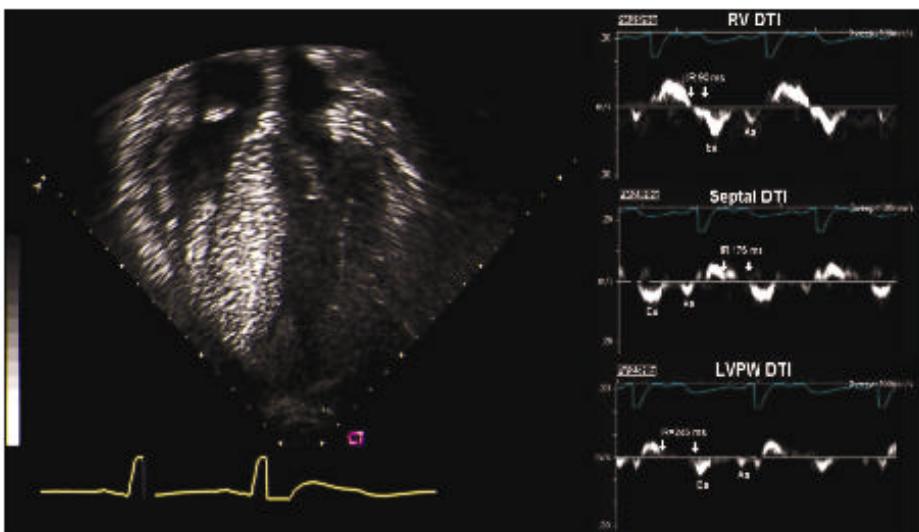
Apical 4 chamber image and pulsed DTI recordings from the left ventricular posterior wall (LVPW), ventricular septum, and right ventricular (RV) free wall in a child with hypertrophic cardiomyopathy. Although the septum appears most affected by 2-dimensional imaging, diastolic dysfunction is identified by DTI in all 3 areas interrogated with prolonged isovolumic relaxation (IR) and decreased early diastolic (Ea) velocities compared to normals. The asynchronous diastolic relaxation properties of different segments of the myocardium in this disease are also evident by the variable IR (90 ms in the RV compared to 246 ms in the LVPW) and variable Ea velocities found at each site.
